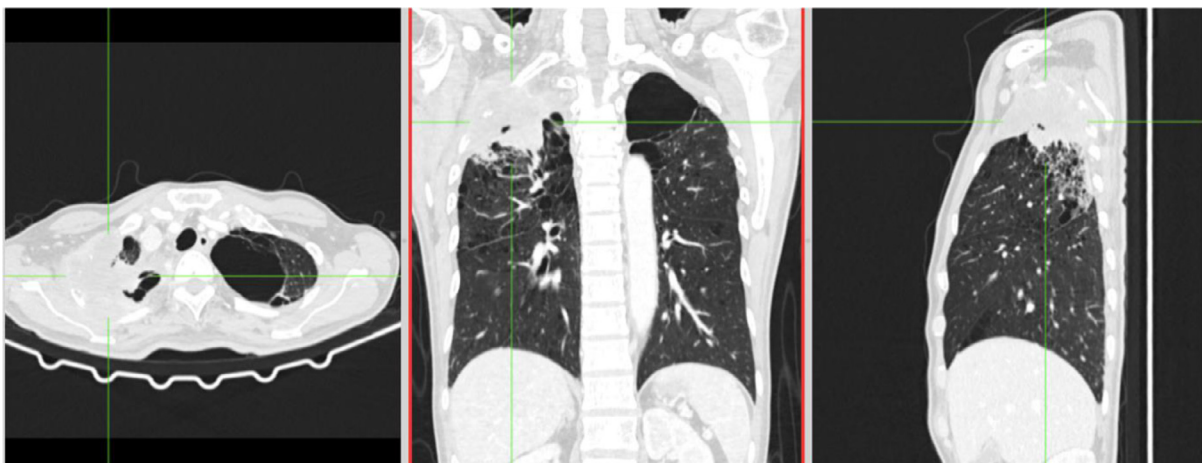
Contrast-enhanced CT-scan images of the chest region after tuberculosis medication shows a heterogeneously enhanced mass with a notable enlargement.
